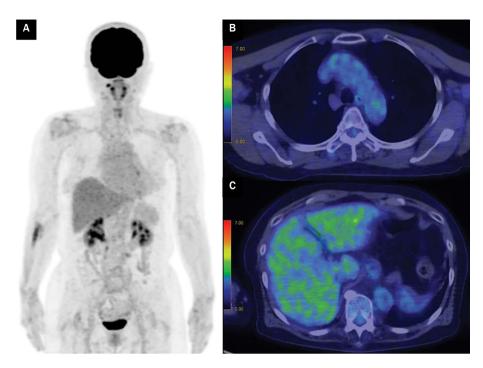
PET/CT image of a representative case with impaired renal function showing increased liver and mediastinal blood uptake. Maximum intensity projection of FDG PET (A), PET/CT fusion image of mediastinal blood pool (B), PET/CT fusion image of liver (C) of a 70-year-old female patient with impaired renal function (eGFR: 48 mL/min/1.73 m²). Parameters of interest were as follows: SUV_{max} of 4.3, SUV_{mean} of 2.8 in liver, SUV_{mean} of 1.9 in mediastinal blood pool
